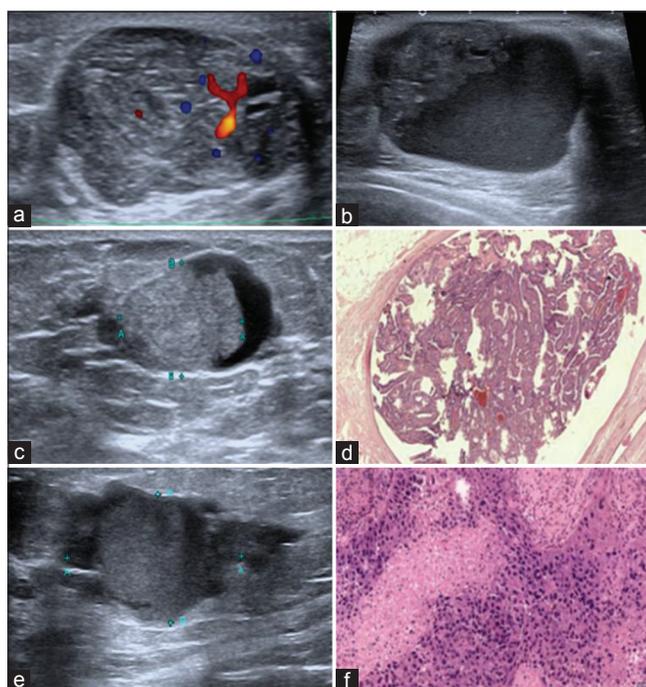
(a) Ultrasound reveals an oval, well circumscribed solid hypoechoic lesion with internal vascularity. HPE – Benign phyllodes tumor; (b) ultrasound shows a large cystic lesion with an eccentric irregular hypoechoic solid component. HPE – Invasive ductal carcinoma; (c) ultrasound reveals an oval well circumscribed solid lesion with eccentric cystic component; (d) HPE – benign intraductal papilloma; (e) Ultrasound reveals an irregular non-circumscribed hypoechoic mass with peripheral cystic changes; (f) HPE – invasive papillary carcinoma
